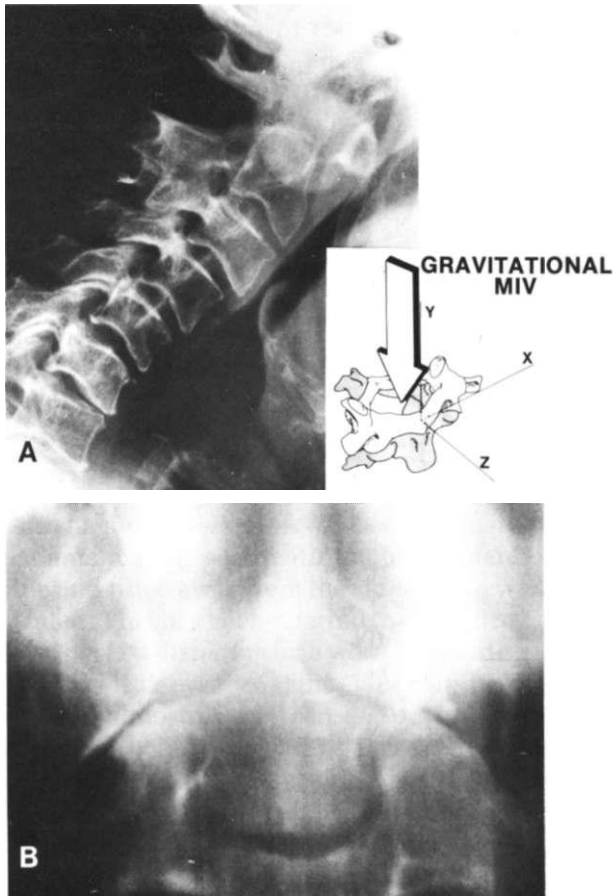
Radiographs of an elderly male with severe rheumatoid arthritis. (A) Vertical subluxation of the axis. This is best described as a vertical ($-y$ -axis) subluxation of the occiput. The dens is at the level of the occipital bone and just at the mouth of the foramen magnum. There is anterior subluxation of C1 on C2 and spontaneous fusion of the lateral masses of C2 and C3. (B) Lateral displacement of the dens and asymmetrical erosion of the lateral mass of C1. The vertical subluxation is largely due to the inadequate supporting structure of the lateral masses. The MIV is primarily the vertical component of the gravitational forces of the head acting over a long period of time on the weakened bone. (Courtesy of Teaching Library, Section of Neuroradiology, Yale University School of Medicine.)
